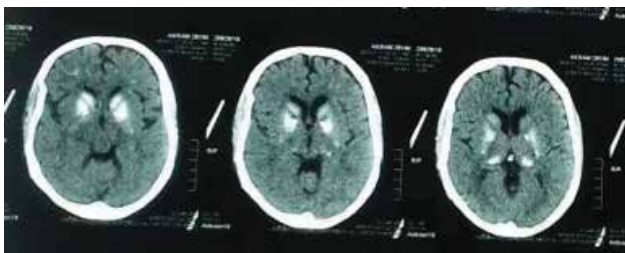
Plain CT scans of the brain
